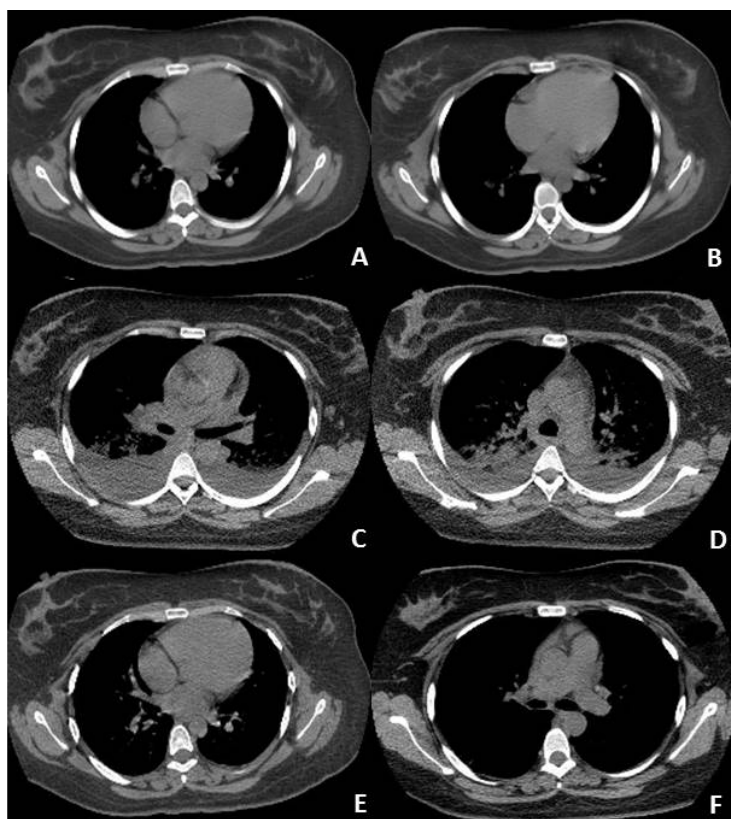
(Computed tomography). A and B: Normal aspect of the thorax on admission; C and D: Bilateral and diffuse areas of ground-glass opacity and consolidations, interlobular septal thickening, bilateral pleural effusions, normal vessels and absence of lymph node enlargement; E: Minimum left pleural effusion; and F: Discrete residual image of atelectasis on the right lung.
